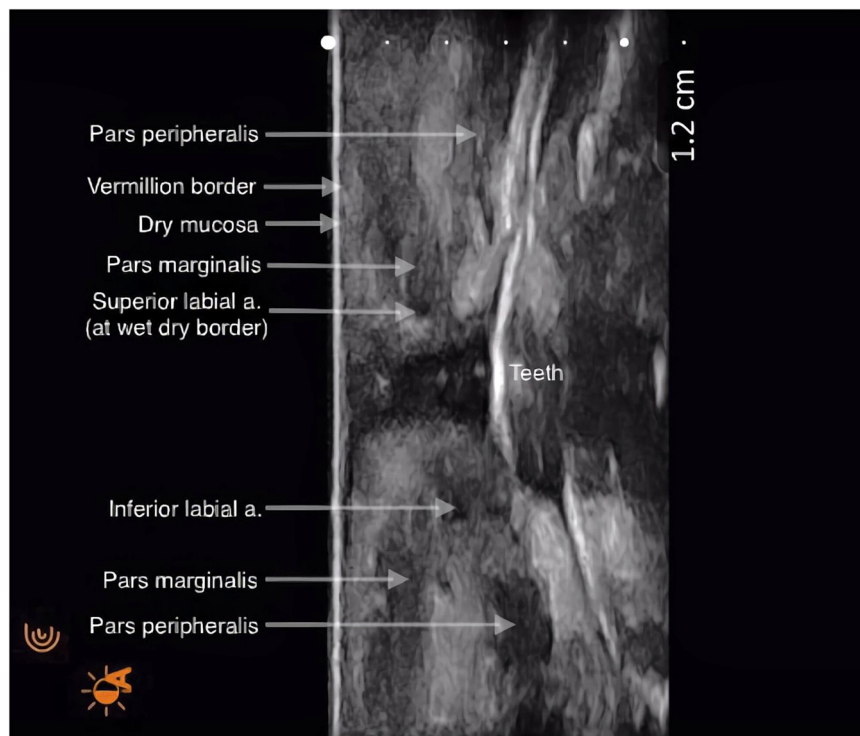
Ultrasonography cross-section image of the lips showing the anatomic landmarks.
